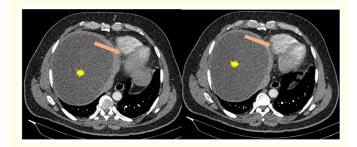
Giant hepatic hydatid cyst with cardiac compression. Axial contrast-enhanced computed tomography (CT) scans demonstrate a large, well-defined hypodense cystic lesion (asterisks) in the right hepatic lobe. The cyst causes significant mass effect, with upward displacement and compression of the right cardiac chambers (arrowheads).
